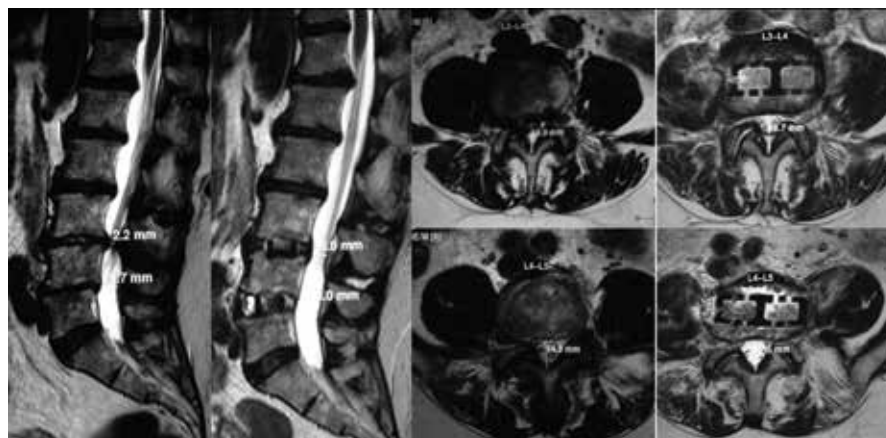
Before and after MRI images showing the ability of LLIF to “open up” the previously tight spinal canal.
